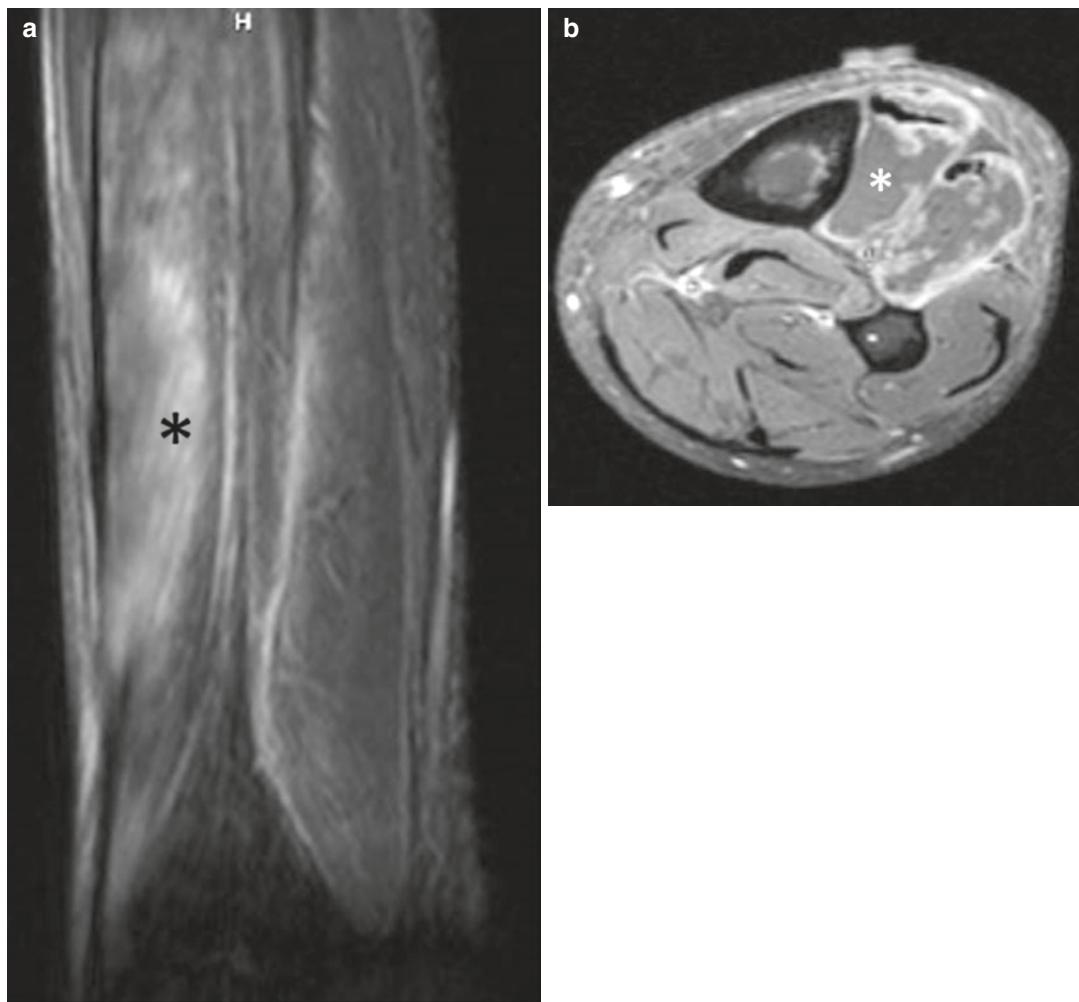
Sixty-four-year-old man with acute onset atraumatic left leg pain with diminished distal pulses 2 days following spinal surgery. Sagittal STIR image of the left leg (a) shows edema and swelling in the anterior compartment musculature (asterisk). Transverse T1-weighted fat-suppressed post-contrast MR image (b)
